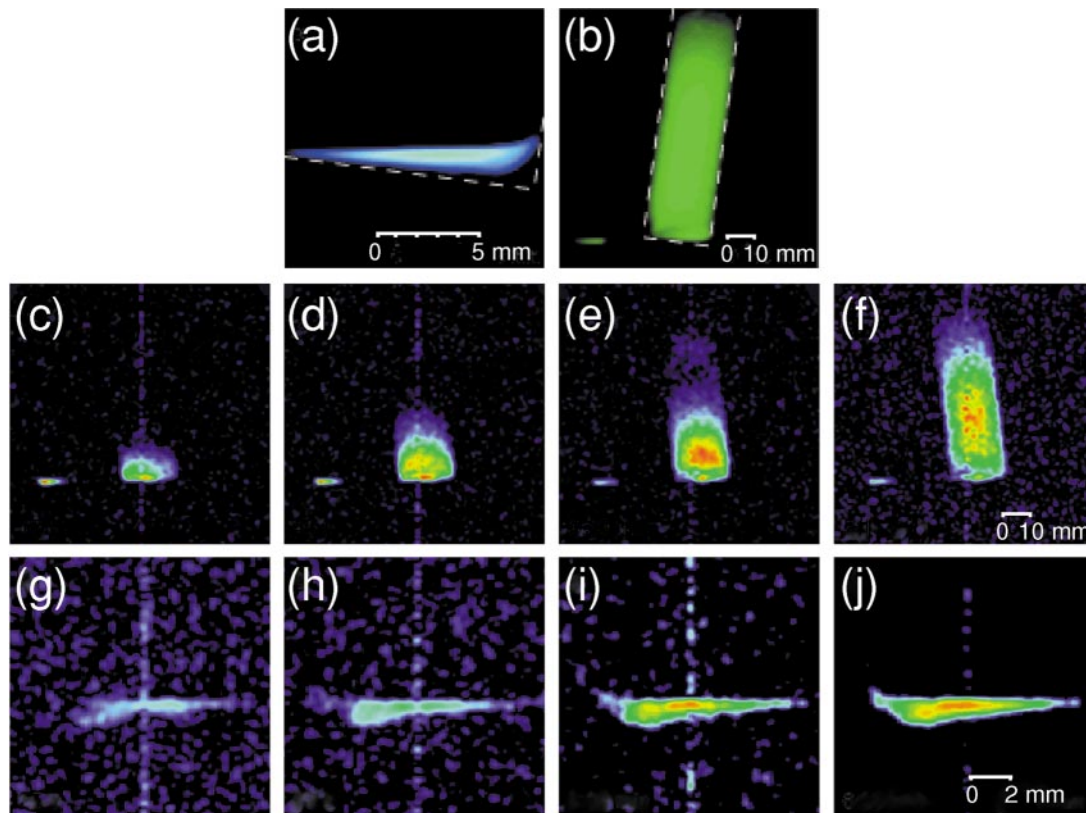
^{129}Xe FLASH MRI of laser-polarized xenon condensed in a tilted glass tube at 166 K (123). (Color) (a) MR image of liquid laser polarized xenon that has condensed at the bottom of the tube. The image resolution was $195 \times 195 \mu\text{m}^2$, limited by the strength of the applied magnetic field gradients. A displaced liquid xenon signal can also be seen in the xenon gas image in (b) resulting from RF-excited xenon atoms in the gas phase condensing into the liquid phase prior to acquisition. (c–f) Time-resolved MR images tracking the evaporation of liquid laser-polarized xenon, taken 12 s (c), 46 s (d), 3:30 min (e), and 5:15 min (f) after the xenon gas signal was destroyed by the application of multiple selective RF pulses and gradient pulses. (g–j) Time-resolved MR images tracking the condensation of gaseous laser-polarized xenon, taken 25 s (g), 63 s (h), 2:30 min (i), and 6:30 min (j) after the xenon liquid signal was destroyed by the application of multiple selective RF pulses and gradient pulses. Figures courtesy of Glenn Wong and Ronald Walsworth.
